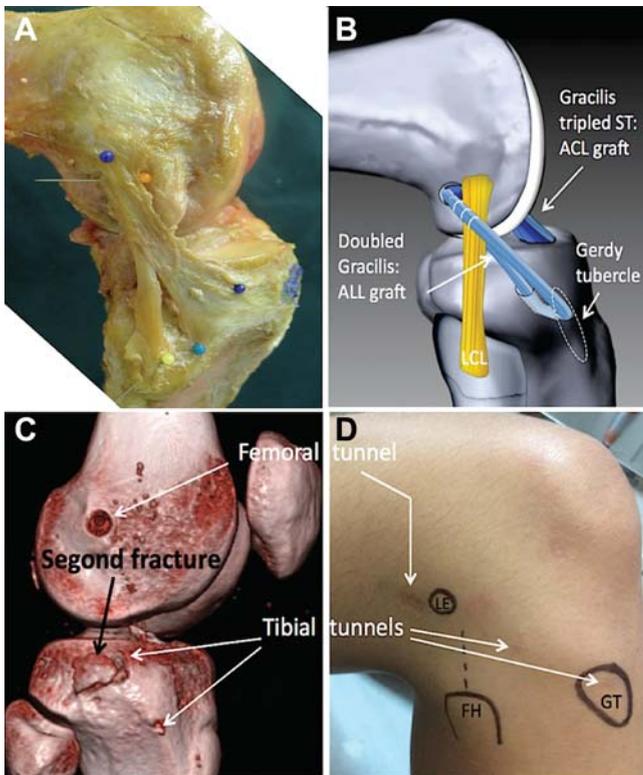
Images of the anterolateral ligament (ALL), the site of the graft, and its surrounding structures. (A) Anatomic, (B) graphic, (C) 3-dimensional computed tomography scan, and (D) surface markings. ACL, anterior cruciate ligament; FH, femoral head; GT, Gerdy tubercle; LE, lateral epicondyle.
